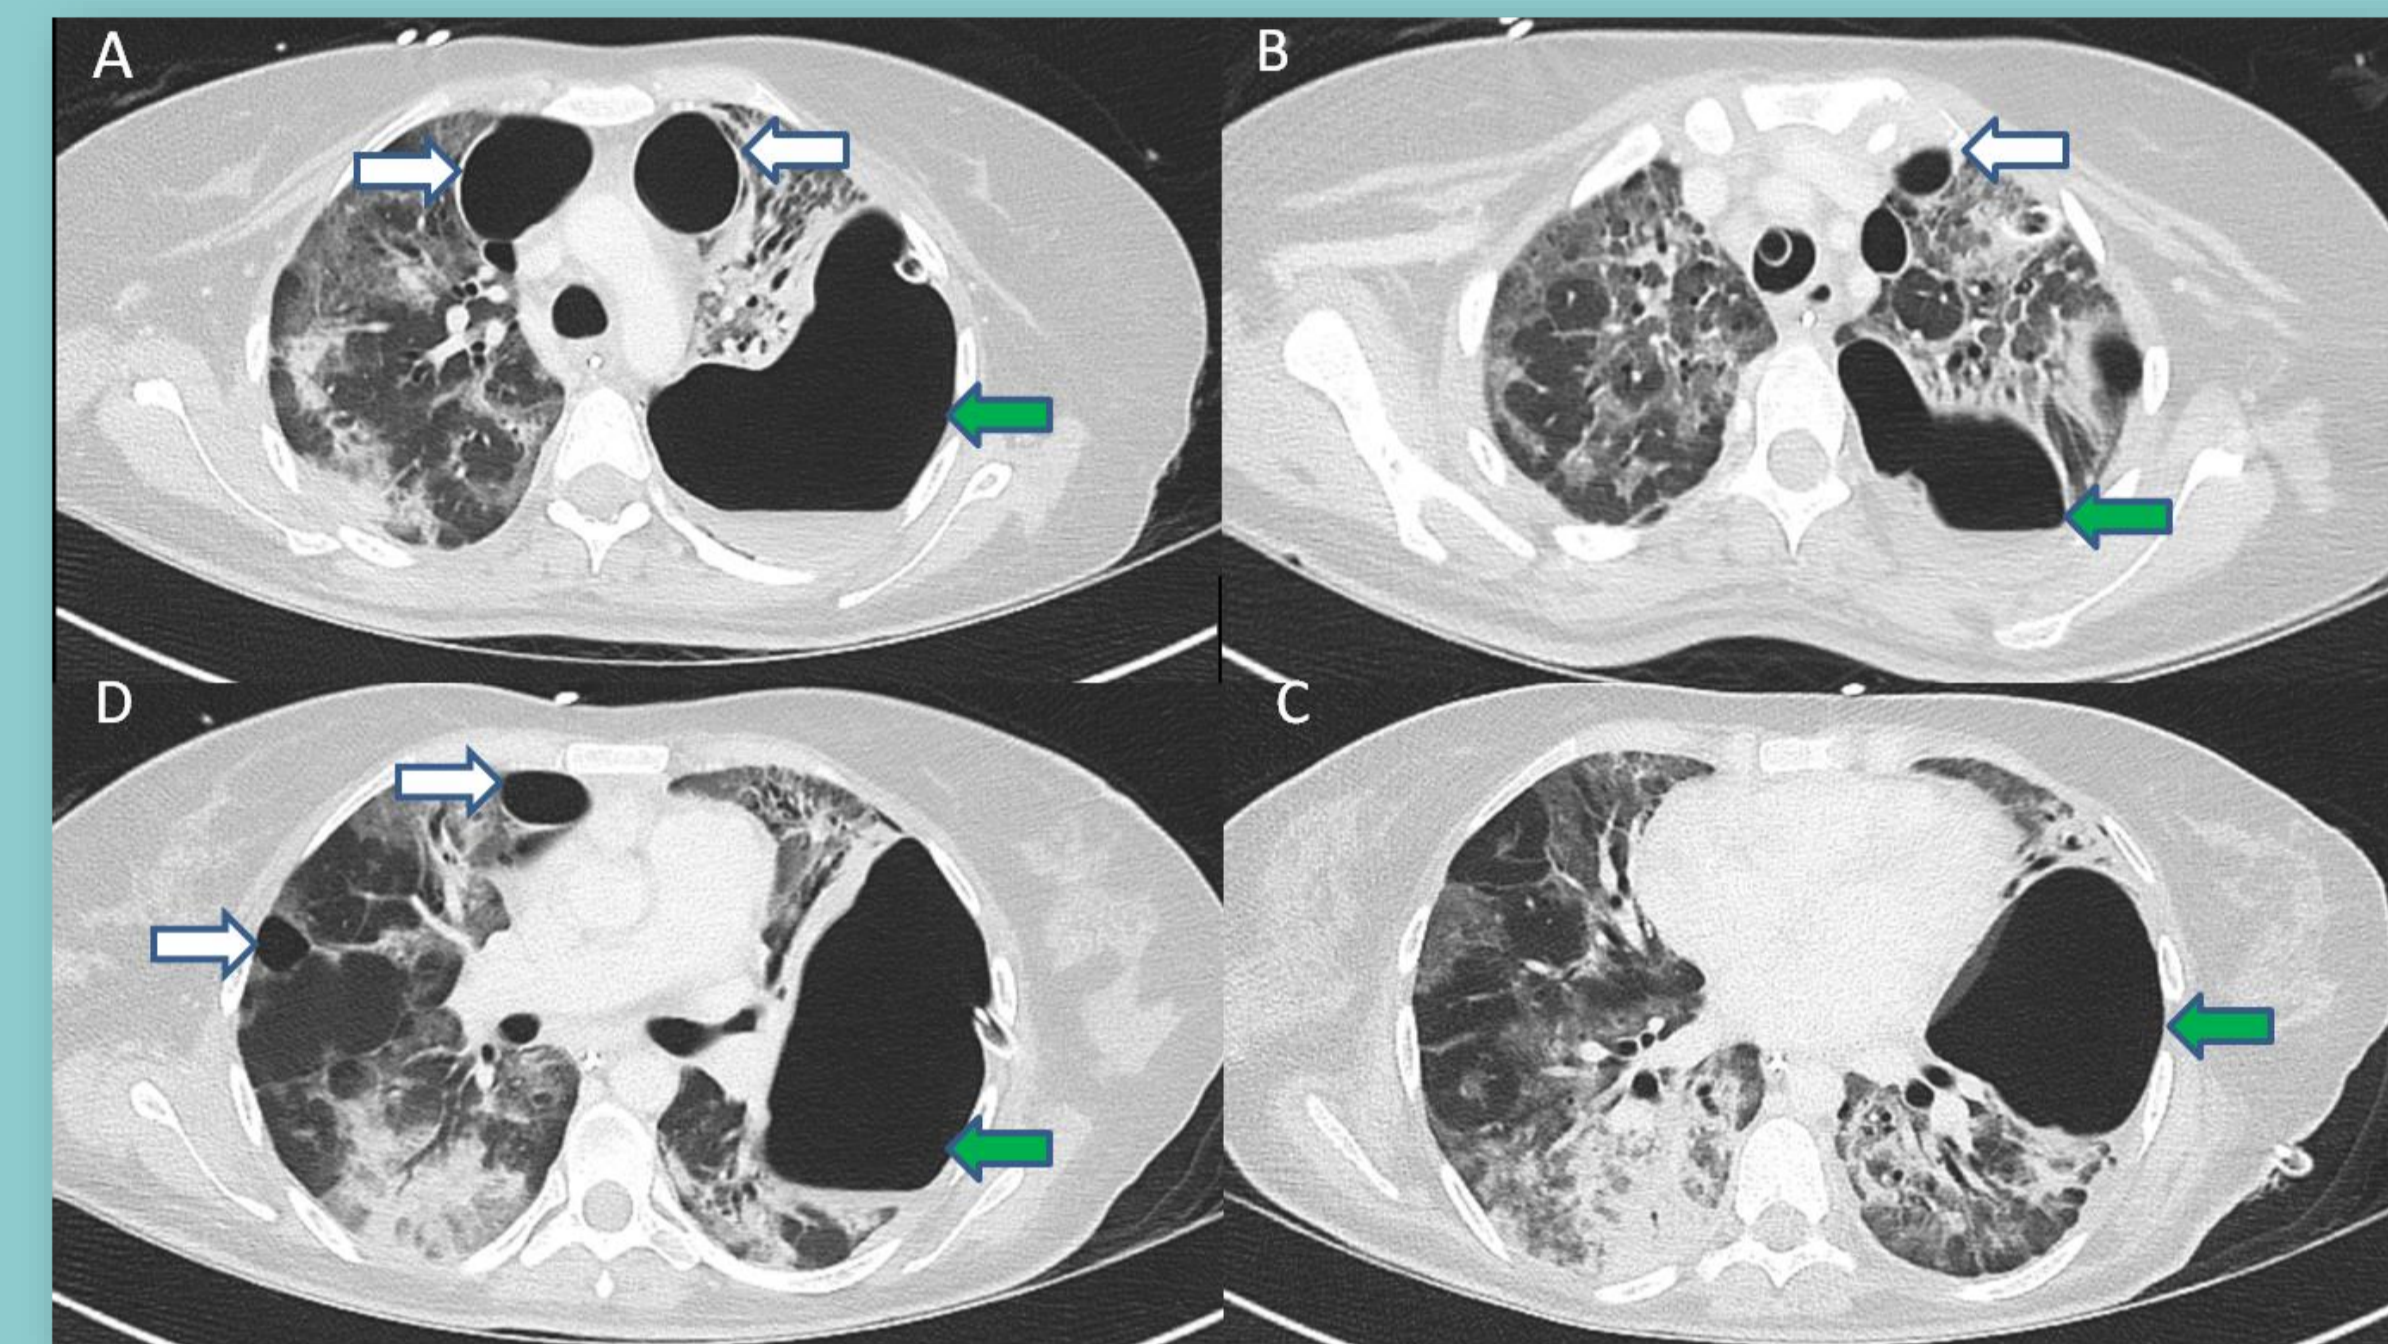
Serial axial sections of thorax computed tomography (CT), post decannulation and for surgical planning. Shows some bilateral scarring from COVID-19 infection, significant improvement in the size of the left hydro-pneumothorax but residual pneumatoceles anteriorly.
